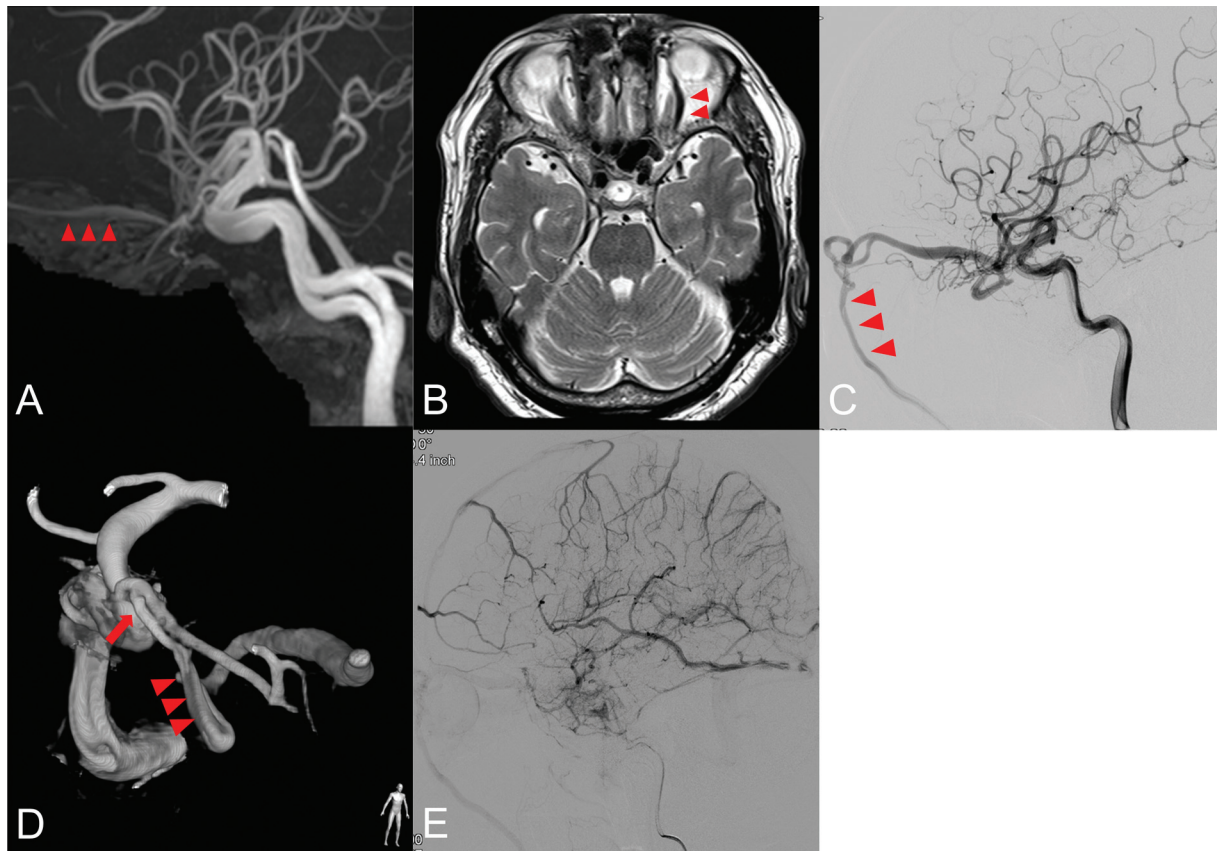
Preoperative imaging. (A) Flow void in the orbit (*arrowheads*) is visualized in magnetic resonance (MR) angiography. (B) Axial T2-weighted MR image showing marked dilation of the left superior ophthalmic vein (SOV) (*arrowheads*). (C) Left internal carotid angiography revealed an arteriovenous shunt between the ophthalmic artery and SOV, which flowed out to the angular and facial veins (*arrowheads*). (D) Three-dimensional digital subtraction angiography (3D-DSA) showed significant meandering of the SOV (*arrowheads*) distal to the shunt point (*arrow*). (E) No obvious cortical reflux or venous stasis was observed in the venous phase of cerebrovascular angiography.
